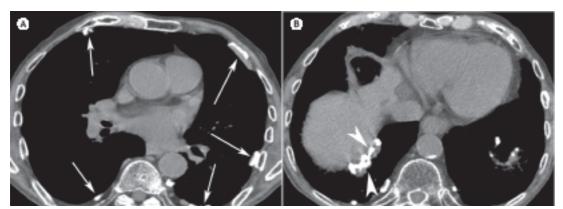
Axial CT scan of the chest, in mediastinal windows at the level of the middle lung regions (A) and lung bases (B), showing multiple pleural plaques, several of them partially calcified (arrows). In B, note the calcified plaques in relation to the diaphragmatic pleura, which are virtually pathognomonic of exposure to asbestos.
